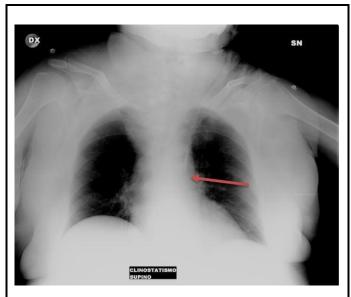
The chest radiograph showed the catheter tip in the hemiazygos vein (red arrow).
